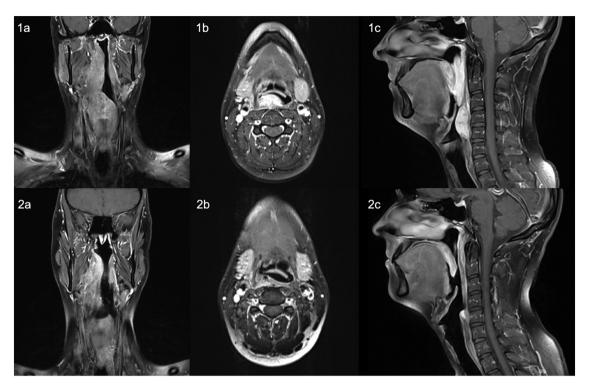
1a-c show the preoperative MRI. 2a-c show MRI at 6-month follow-up, revealing minor cicatricial changes in the right oro- and hypopharynx and unchanged residual lesion in rhinopharynx.
